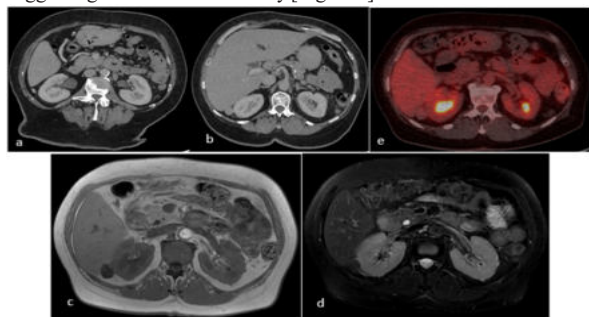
(a) & (b) Axial post-contrast CT in portal venous phase
